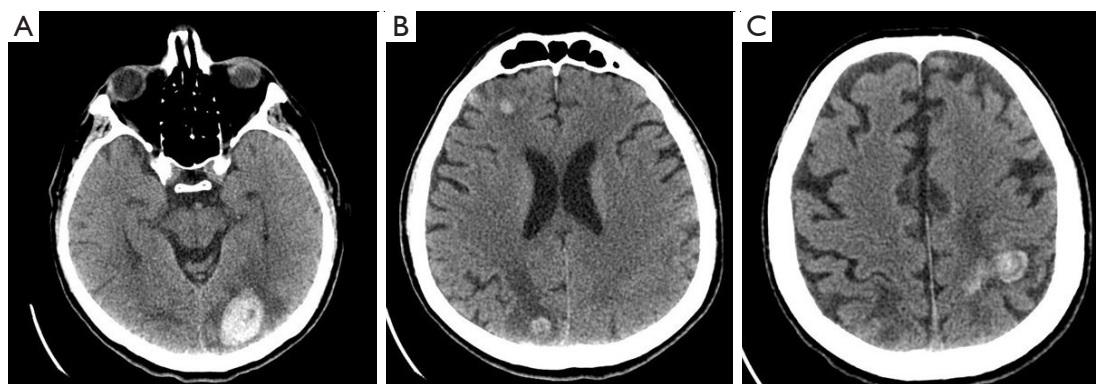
Unenhanced axial brain CT images, with multiple lesions in both hemispheres. (A) Focal lesion in the occipital lobe, with hemorrhagic changes and surrounding edema. (B) Two other focal lesions with edema and slightly hemorrhagic. (C) A parietal sulcal hemorrhage with surrounding edema. CT, computerized tomography.
